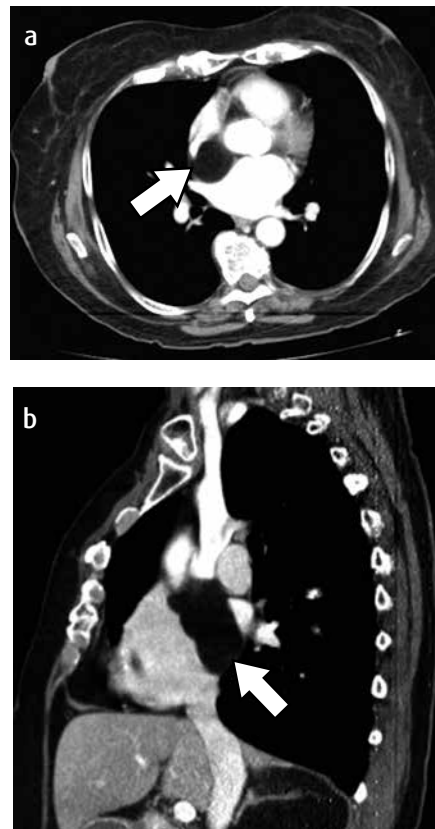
a) Axial CT, b) Sagittal reconstruction. Low fat density image, localized in the middle mediastinum that corresponds to lipoma (arrows).
